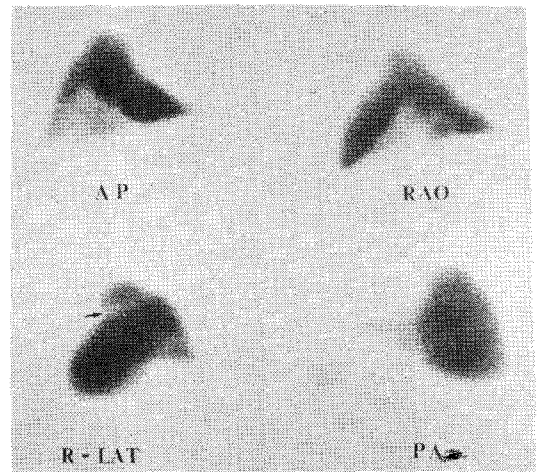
Hepatic scintigram showing characteristic bulge with a ring of constriction on all of images. There is a band-like photon defect at the neck of the superior bulge on right lateral view (arrow).
